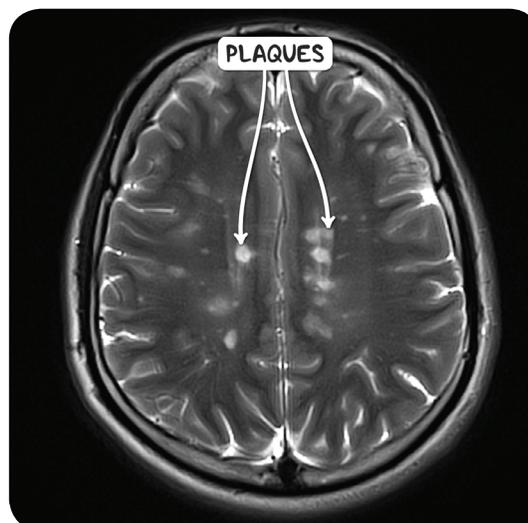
An MRI scan of the head in the axial plane demonstrating the multiple demyelinating plaques present in the brain of an individual with multiple sclerosis.
